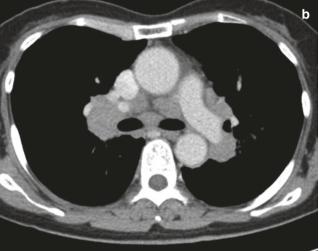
Sarcoidosis with bilateral hilar lymphadenopathy. (a) Frontal radiograph shows lobular opacities in both hila while the pulmonary arteries can be seen through them (positive "hilum overlay" sign). The lower lobe pulmonary artery branches do not converge on the enlarged hilum ("hilum convergence" sign is absent) suggesting that the enlarged hilum is not due to dilated pulmonary arteries. (b) Axial CT image confirms the finding
